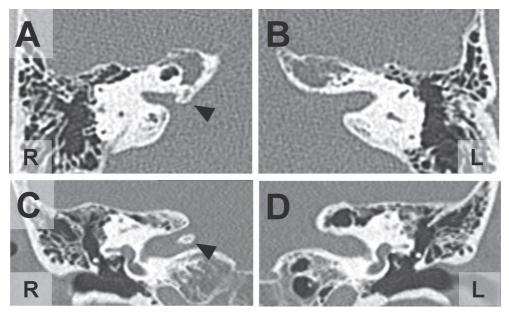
CT scans of the temporal bone.
